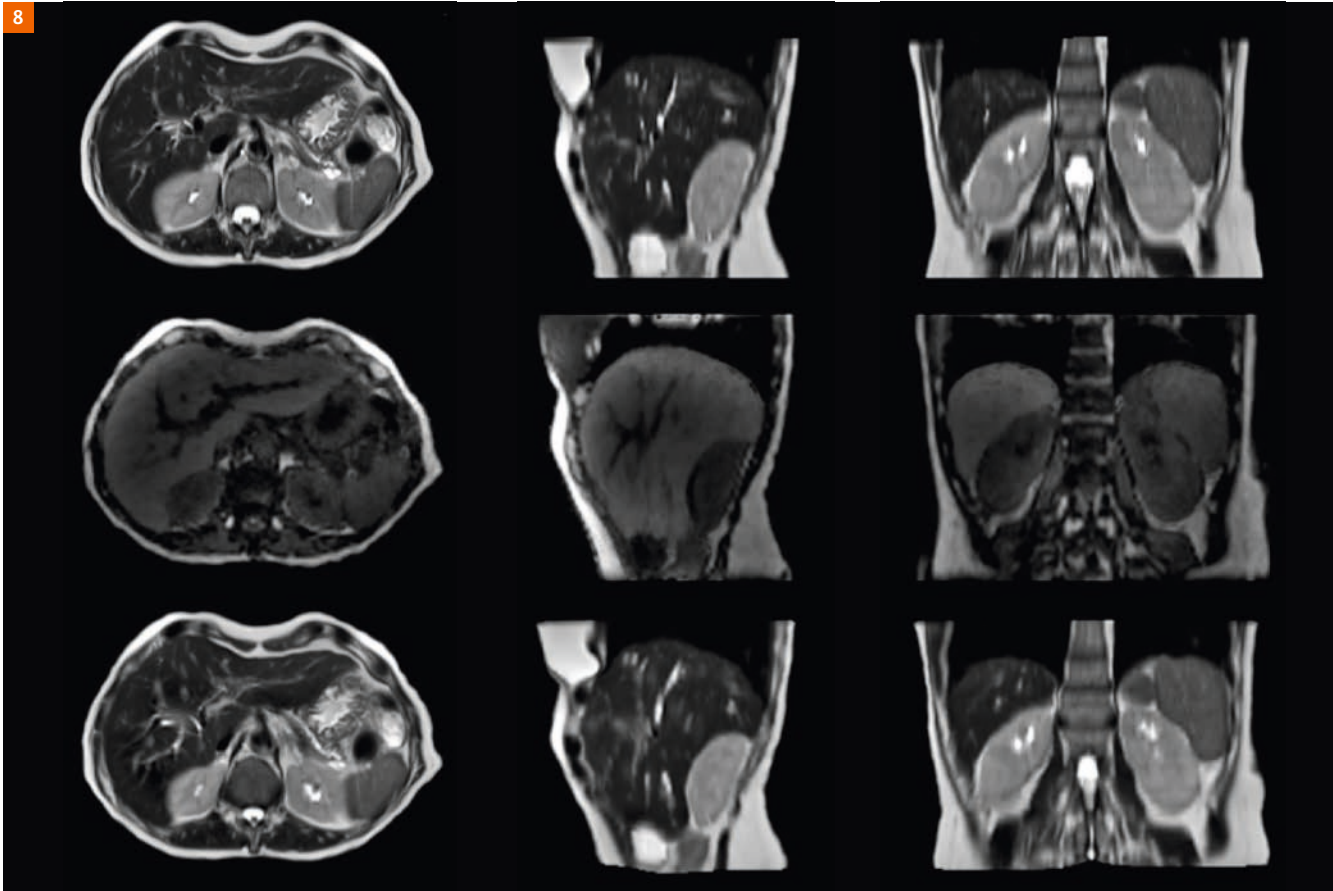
Demonstration of using 4D-MRI as a vehicle. Respiratory-triggered T2 TSE images acquired at end expiration (top row) are transformed to a mid-position anatomical state (middle row) using 4D-MRI and deformable image registration. This process permits image contrasts to be obtained at one respiratory phase more favorable for acquisition, and then transformed to another phase more favorable for treatment delivery (bottom row).
